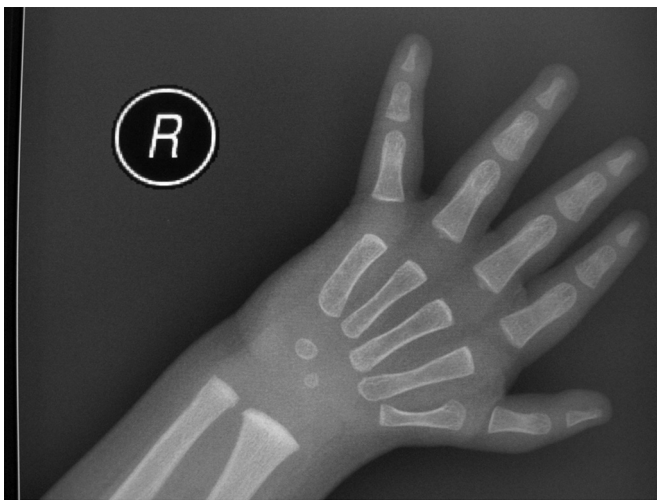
Radiography of the right hand of H.L. showing hypoplasia of the right first metacarpal shaft.
